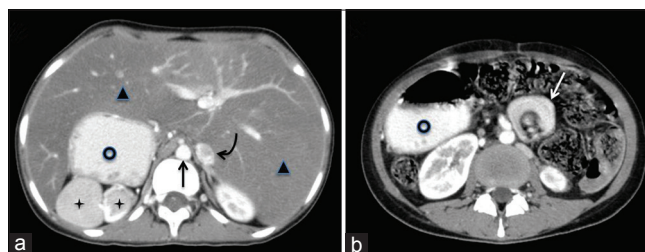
(a and b) Contrast-enhanced axial computed tomography image through the upper abdomen. There is evidence of polysplenia (+) with the stomach lying on the right side (O) and the liver lying in the midline (▲). The inferior vena cava (curved arrow) is lying to the left of the aorta (arrow) which is midline in location. There is malrotation of bowel with whirling of the mesenteric vessels suggesting midgut volvulus (white arrow)
